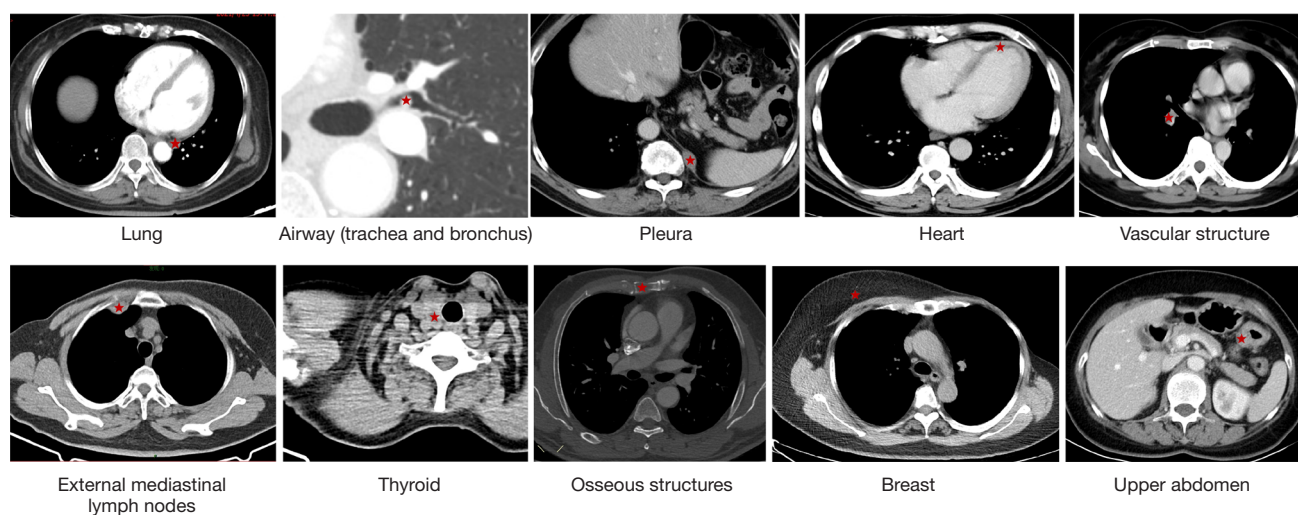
Summary of blind spots on chest CT (red star indicates the areas of common blind spots on chest CT). CT, computed tomography.
